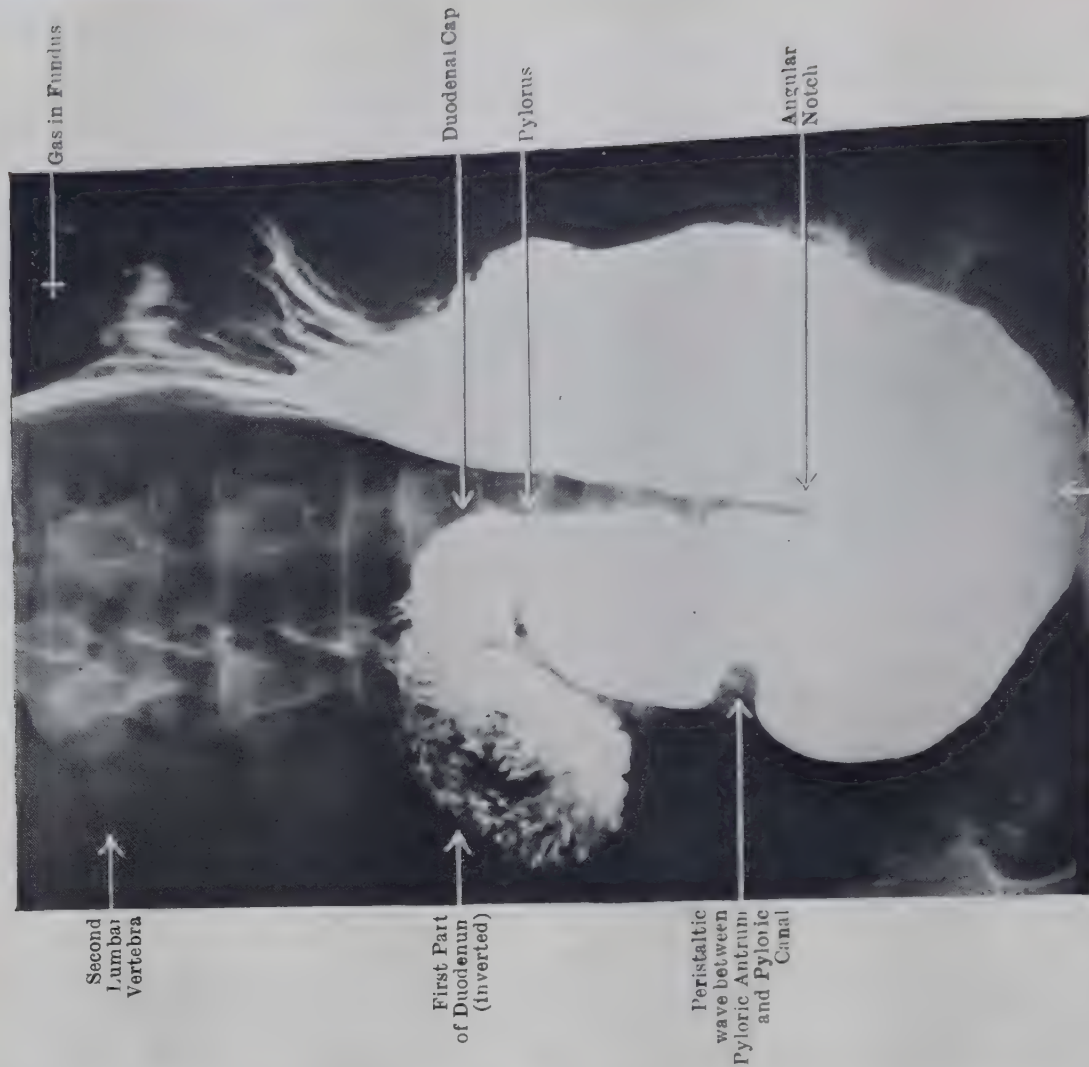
RADIOGRAPH OF STOMACH IN VISCEROPTOSIS.
